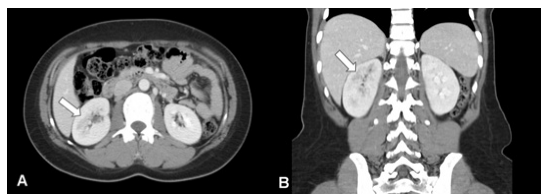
Pyelonephritis exhibited on the right kidney, but subcutaneous emphysema was absorbed from the axial view (A) and coronal view (B) on CT after 5 days
